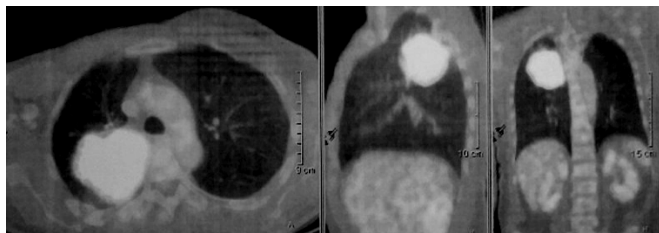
Positron emission tomography (PET/CT) of patient
